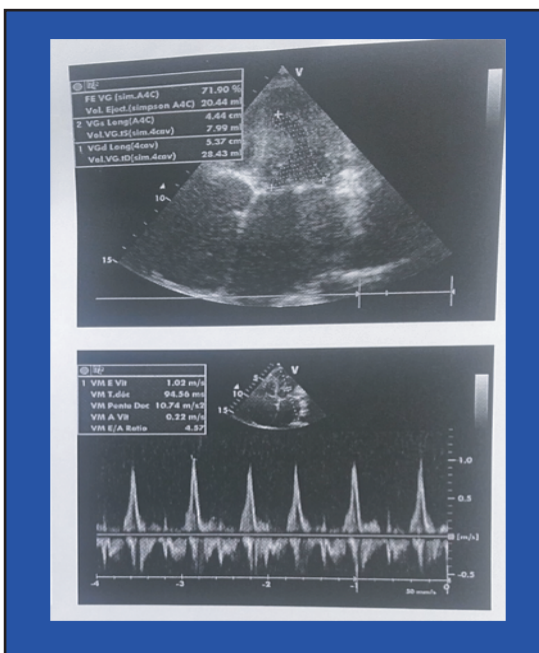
Mitral Doppler echocardiogram Restrictive filling (E/A>1.5) and short deceleration
